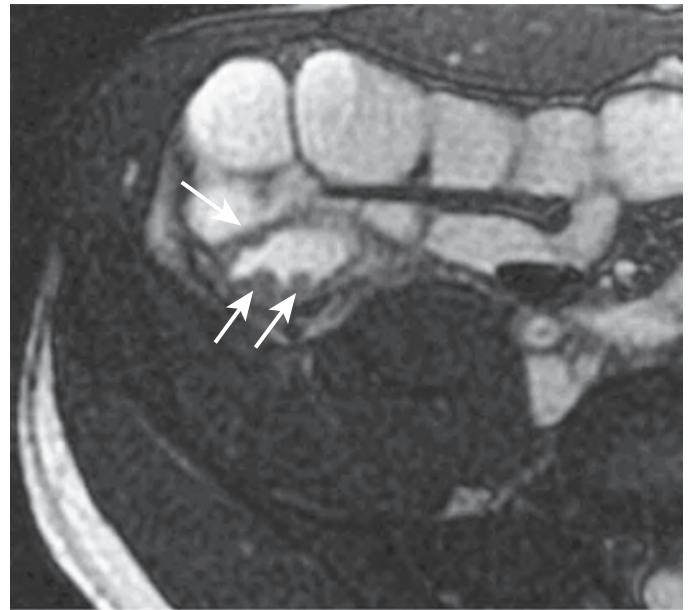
Inflammatory pseudopolyps: MRI features. Axial true FISP scan of the distal ileum shows pseudopolyps as small nodular defects protruding through the thickened bowel wall (arrows).
